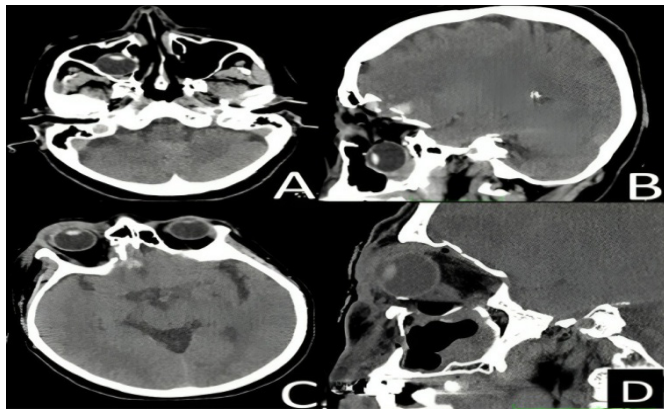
Preoperative and postoperative CT imaging of globe dislocation to the maxilla after trauma: A) Axial imaging shows intact globe dislocation to the maxilla as a result of orbital inferior wall fracture. B) Orbital inferior wall fracture and dislocation of the globe to the maxilla on sagittal imaging. C) In postoperative day 1 axial CT imaging, the globe was repositioned into the orbit. D) Inferior wall stability was achieved with the polyethylene mesh seen on the inferior wall in the sagittal CT examination on postoperative day 1
